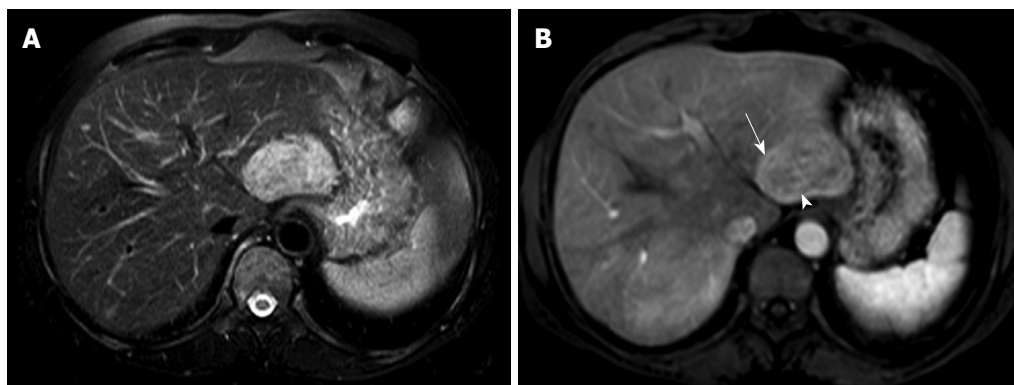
46-year-old woman with epithelioid angiomyolipoma in left lobe of liver (patient 9). A: Non-enhanced MRI T2WI shows hyperintense lesion in segment II/III; B: Contrast-enhanced MRI shows obvious enhanced lesions with outer rim enhancement (arrow) and opacification of punctate or curved vessels (arrowhead) on arterial phase.
